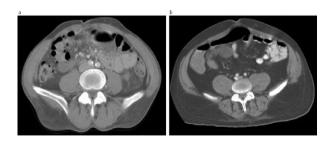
Computed tomography image at vertebral level L4, depicting trunk adiposity distribution and muscle size in: (a) a 53 year old, typically-developed male (65kg body mass), and (b) a 54 year old male with CP (66kg body mass).
